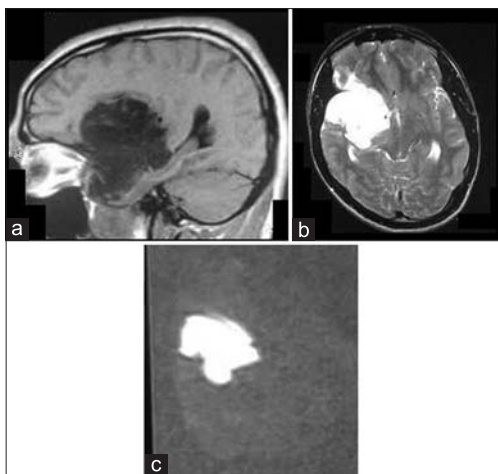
Preoperative images of a 24-year-old male with right sylvian fissure epidermoid cyst. (a) Sagittal T1-weighted image showing the hypointense lesion in the sylvian fissure. (b) Axial T2-weighted image showing the hyperintense epidermoid with compression of the midbrain. (c) Diffusion-weighted image showing the restriction
